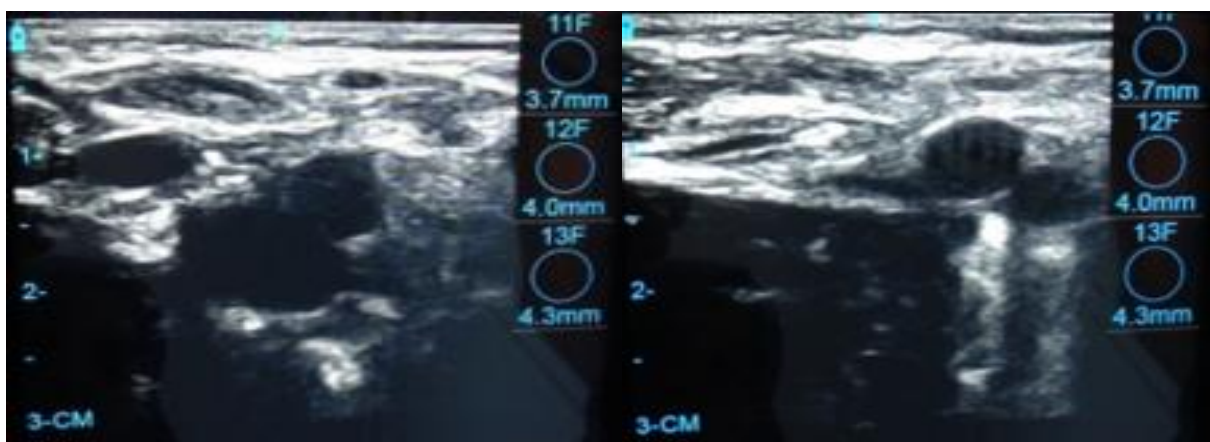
Appearance of vascular structures on ultrasound.
